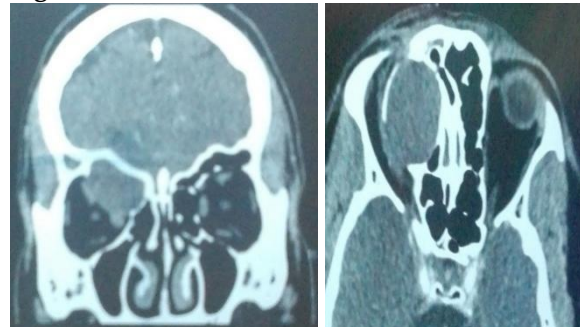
CT image of Case 1
